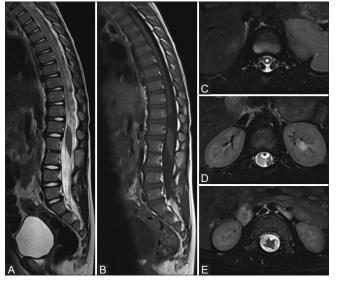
(A-E): MRI dorso-lumbar spine: Sagittal T2WI (A) and Sagittal T1WI (B) shows a significantly thinned segment of lower dorsal spinal cord (from mid D12 to mid L1) with mildly bulky spinal cord and conus caudal to it. Axial fat sat T2WI (C), (D and E) above, at and below the level of spinal cord narrowing respectively. Normal cord caliber with syrinx in (C), significantly thinned spinal cord with no nerve root at (D) and mildly bulky distal cord (E)
